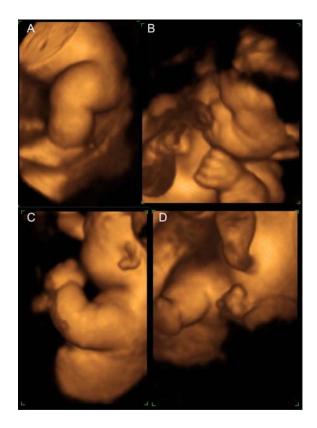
Three-dimensional ultrasound images at 30 weeks of gestation images showing (A) increased subcutaneous tissues in the lower limbs, (B) frontal bossing and a depressed nasal bridge, (C) short upper limbs, (D) short lower limbs
